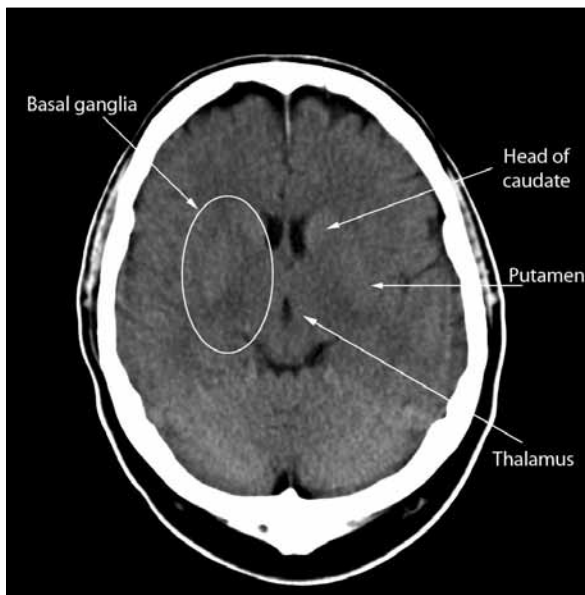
An axial slice from an unenhanced computed tomography scan demonstrating the head of the caudate nucleus, putamen of the lentiform nucleus and the thalamus. Collectively they make up the basal ganglia.
